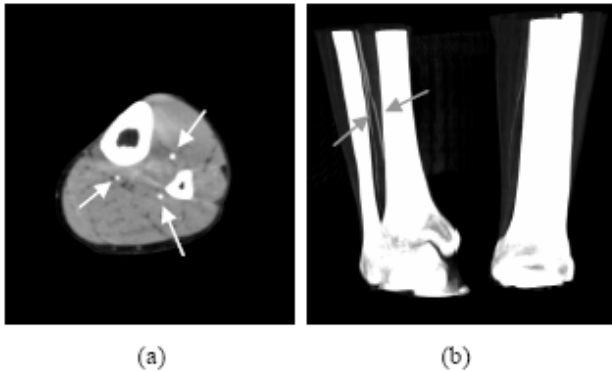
An example of CTA: (a) shows a 2-D CTA and (b) shows a MIP image of CTA images. The arrow areas show the artery regions
